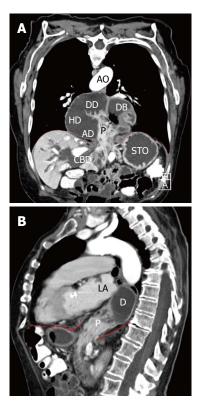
Computed tomographic scan obtained after oral administration of contrast. A: Frontal plane; B: Sagittal plane. The duodenum (D) lies dorsal to the atrial chambers. The descending duodenum is in immediate proximity to the left atrial (LA) chamber. The diaphragm is pointed out as the red dashed line. P: Head of pancreas; CBD: Common bile duct; STO: Stomach; DB: Duodenal bulb; DD: Descending duodenum; HD: Horizontal duodenum; AD: Ascending duodenum; AO: Aorta.
